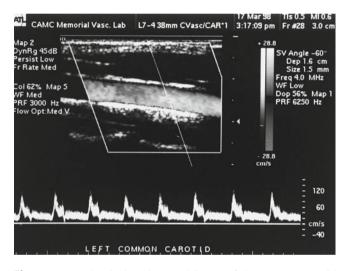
A color duplex ultrasound image of the common carotid artery. The common carotid artery signal has a flow characteristic of both the internal and external carotid arteries
